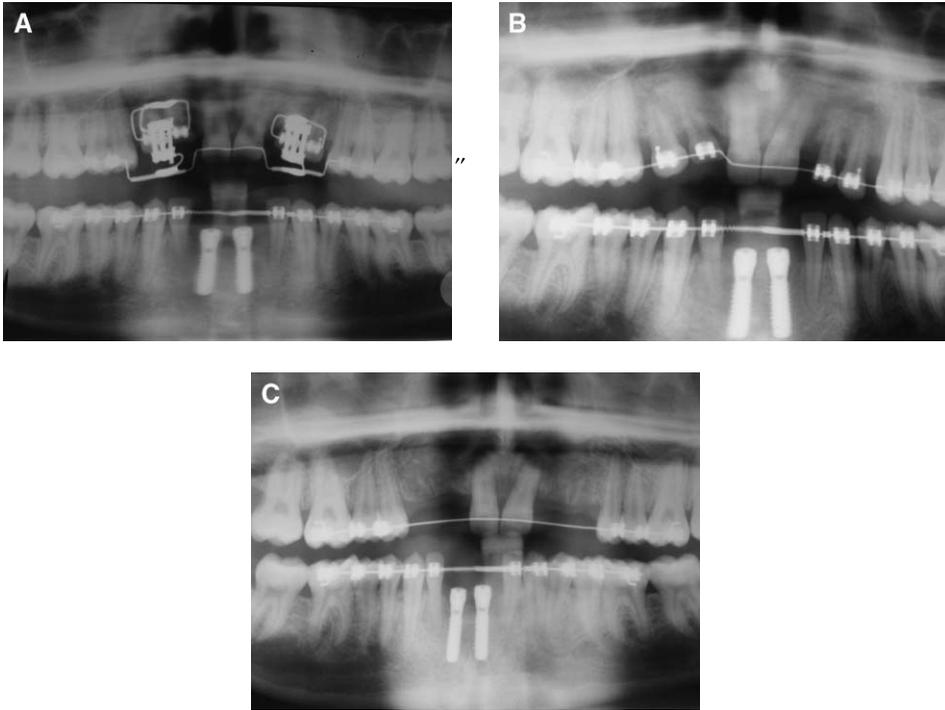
(A) Immediate postoperative panoramic radiograph shows device position. (B) Panoramic radiograph after distraction device removed shows increased vertical height of alveolus and teeth. (C) Panoramic radiograph after extraction of deciduous teeth shows increased vertical height of alveolus.
